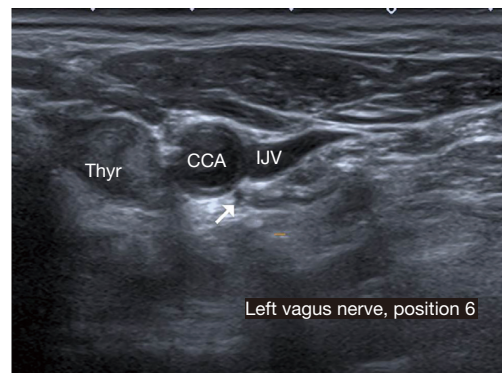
Ultrasound aspect of the left vagus nerve (white arrow) in position 6. THYR, thyroid lobe; IJV, internal jugular vein; CCA, common carotid artery.
